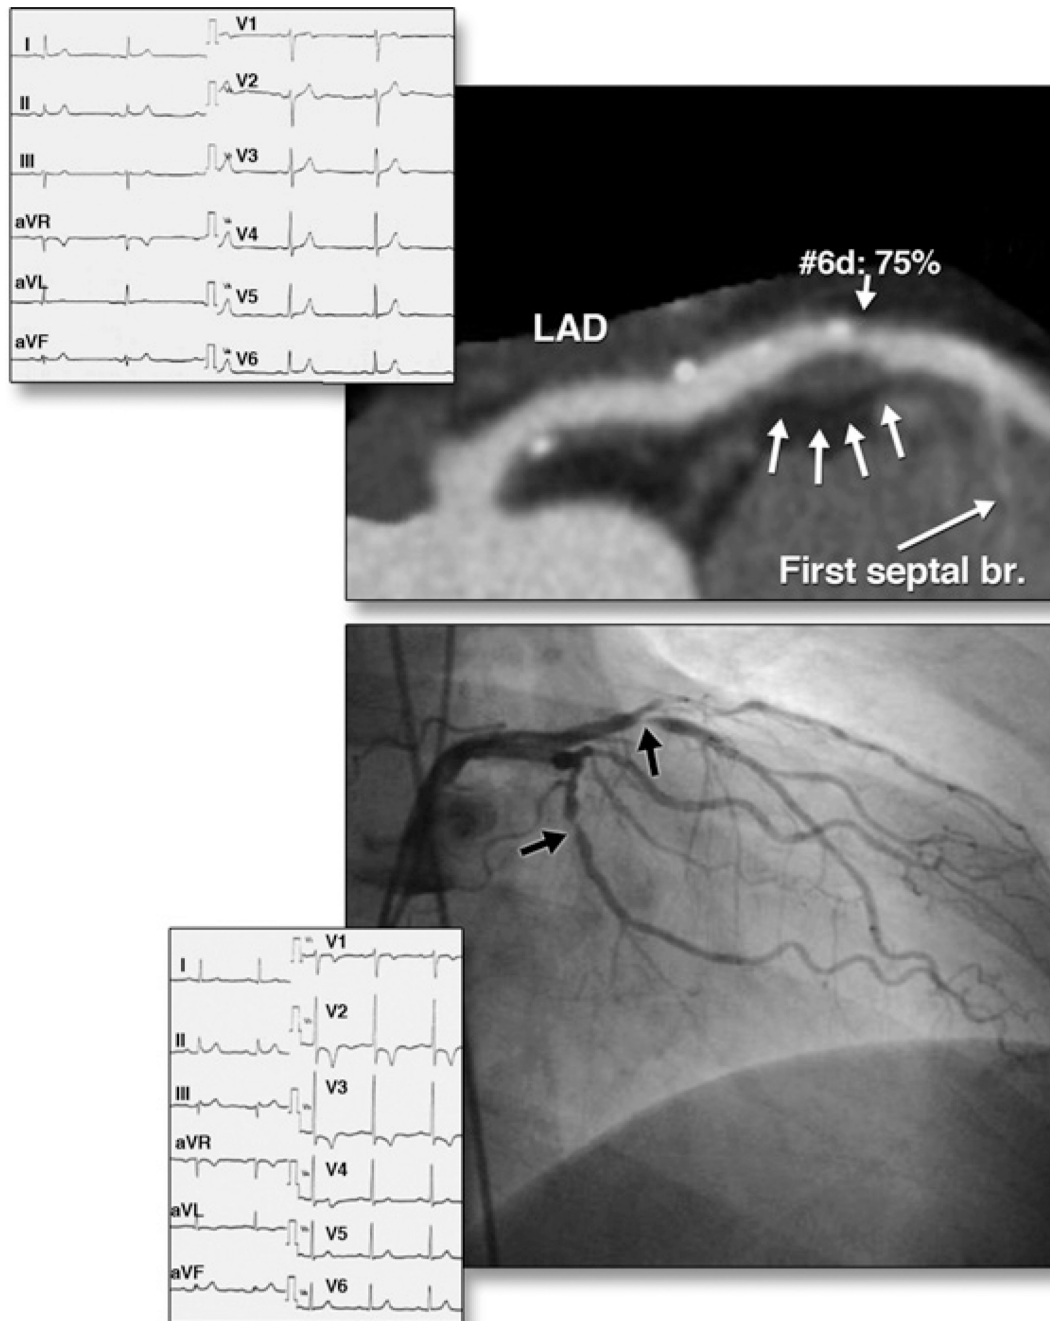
Morphological Characteristics on Coronary CTA of an Atherosclerotic Lesion Resulting in ACS
